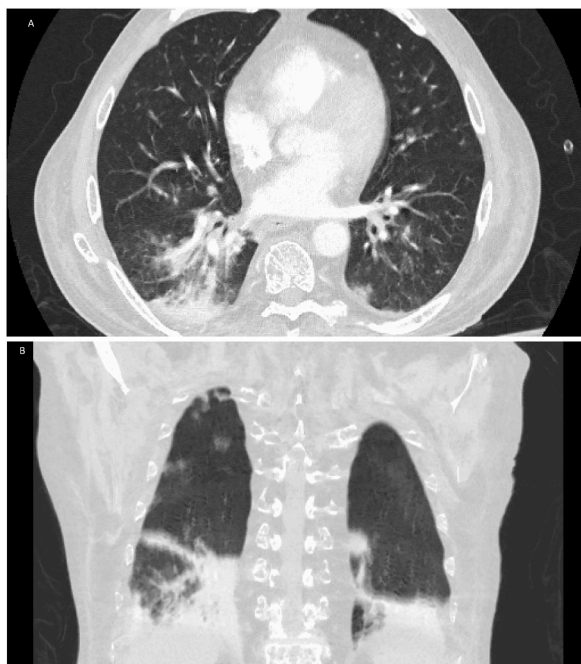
A&B: Chest computed tomography axial and coronal views with bilateral patchy infiltrates, tree-in-bud opacities, and bronchial wall thickening.
